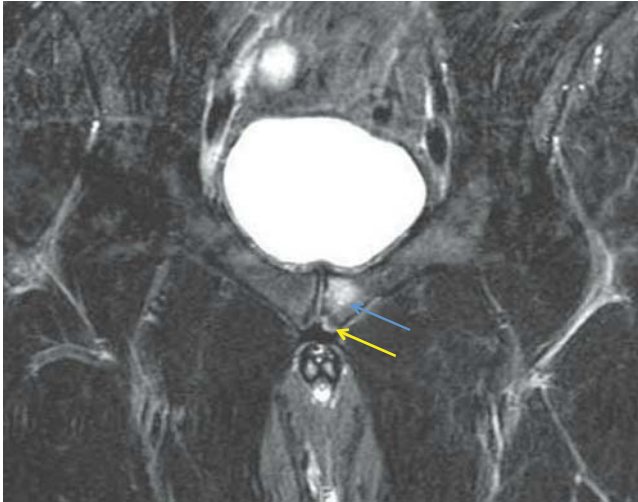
MRI of pelvis in an athlete with athletic pubalgia. Shown is edema in the parasymphyseal region of the pubis and secondary cleft sign (*arrows*) indicating aponeurotic lesion associated with this condition.
